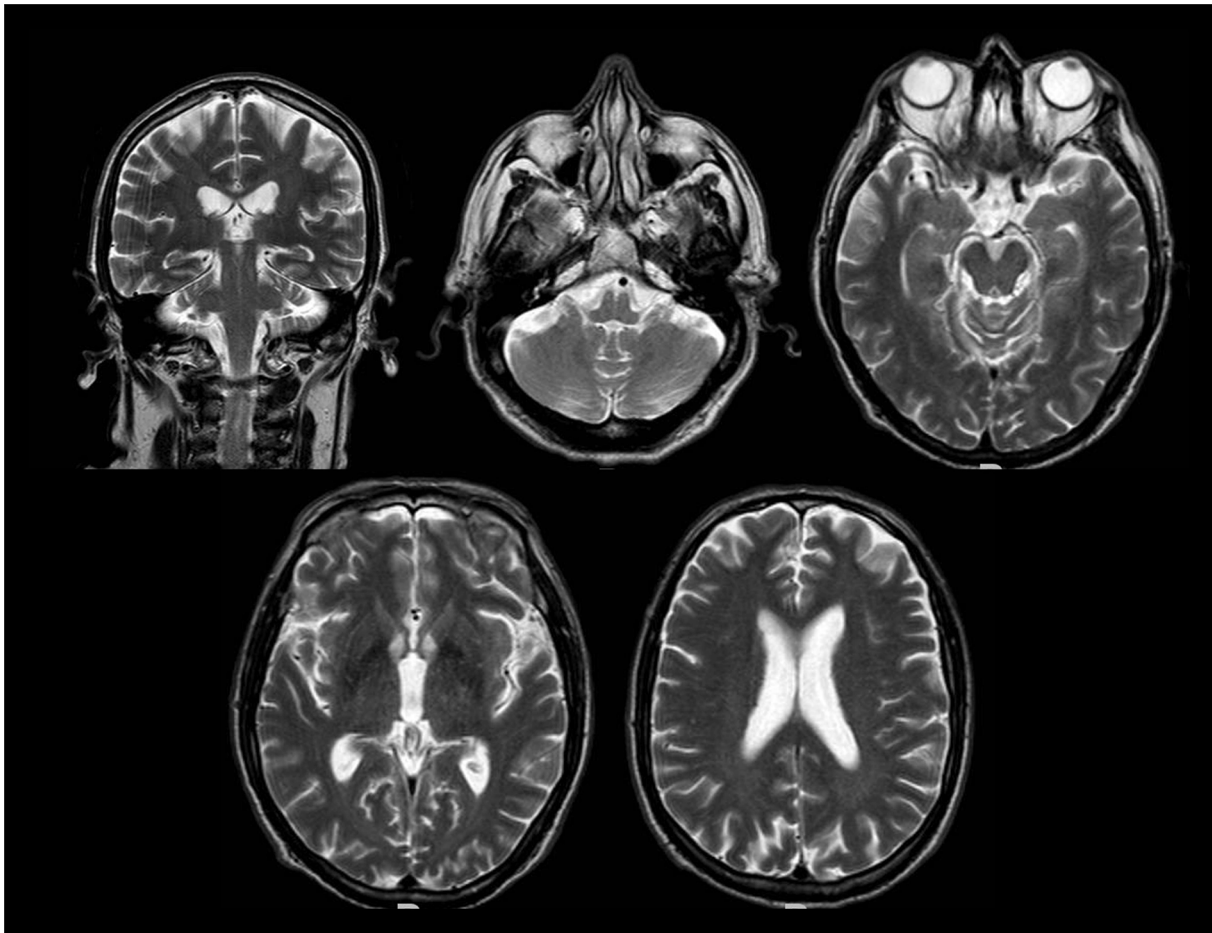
Brain MRI demonstrating no focal lesions. Coronal and transverse T2-weighted images.
